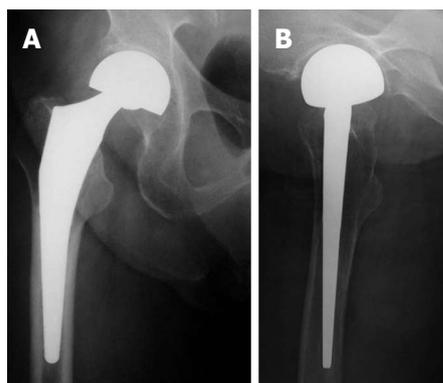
Since the anteroposterior width of Accolade TMZF stem is narrow and rasping of the greater trochanter is not necessary, this stem could be readily used for the direct anterior approach. Anteroposterior and lateral views on X-ray radiography after bipolar hemiarthroplasty.
